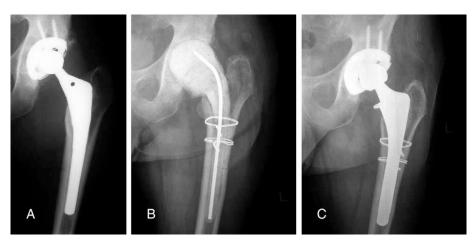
Case of successful 2-stage exchange with an ETO. (A), Preoperative radiographs. (B), Postoperative radiographs after removal of the implant; an ETO was necessary to remove this well-fixed stem after traditional methods failed. (C), Final follow-up radiographs at 36 months.
